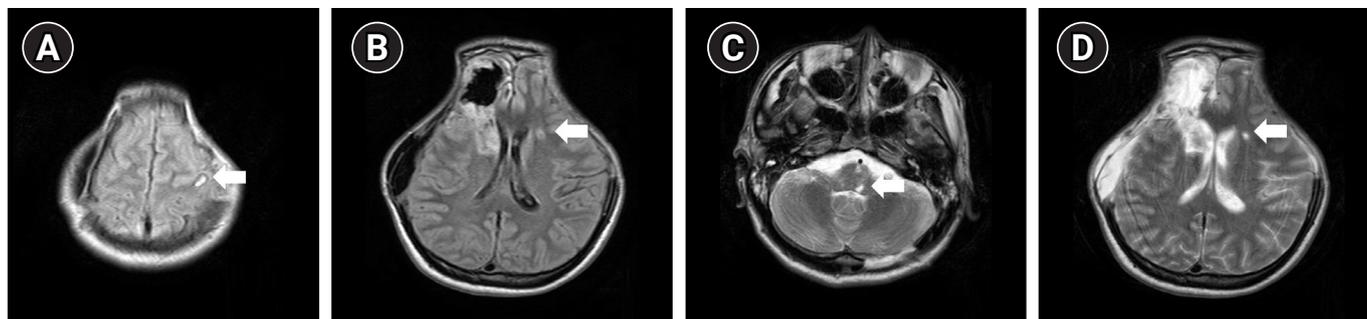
Brain magnetic resonance imaging of the patient taken 1 month after the initial injury. T2-weighted images including fluid-attenuated inversion recovery (A, B) and turbo spin echo (C, D) sequences showed hyperintensities in the left cerebral hemisphere and brainstem, indicating lesions of subcortical white matter, which demonstrated diffuse axonal injury (white arrows).
